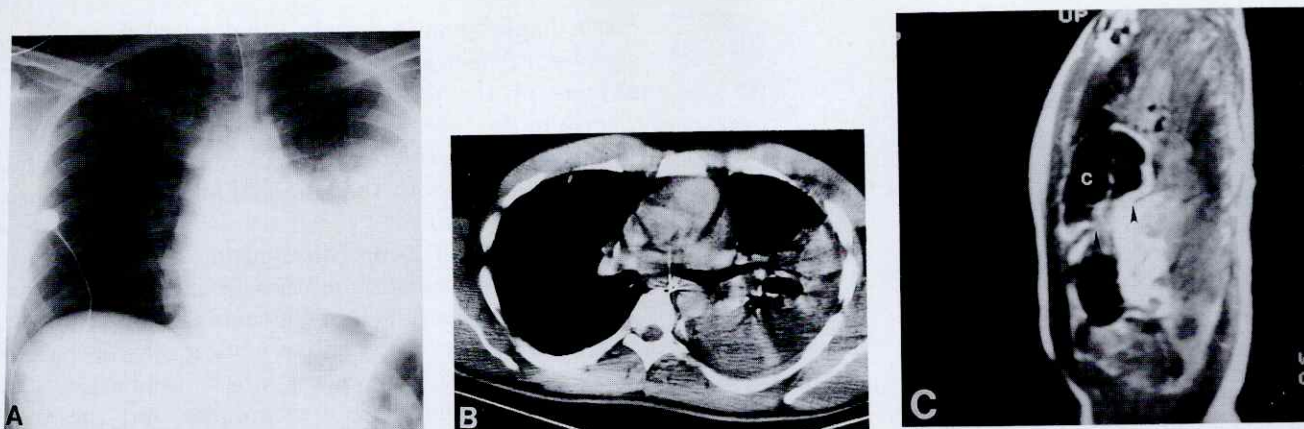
Magnetic resonance images of diaphragmatic rupture: (A) Admission chest x-ray film in a 28-year-old man injured in a left broadside car collision revealed apparent elevation and poor definition of the left hemidiaphragm and increased density in the left lower hemithorax. (B) A CT image through the lower thorax demonstrated an air-fluid level with surrounding consolidation at the left base. The finding was considered consistent with herniated bowel or a traumatic lung cyst with surrounding consolidation. (C) A parasagittal T₂-weighted MRI scan through the left hemidiaphragm showed unequivocal herniation of colon (c) through a tear in the hemidiaphragm (arrowheads). (Reprinted with permission from Mirvis SE, Keramati B, Buckman R, et al: MR imaging of traumatic diaphragmatic rupture: Report of a case. *J Comput Assist Tomogr* 12: 147, 1988.)
